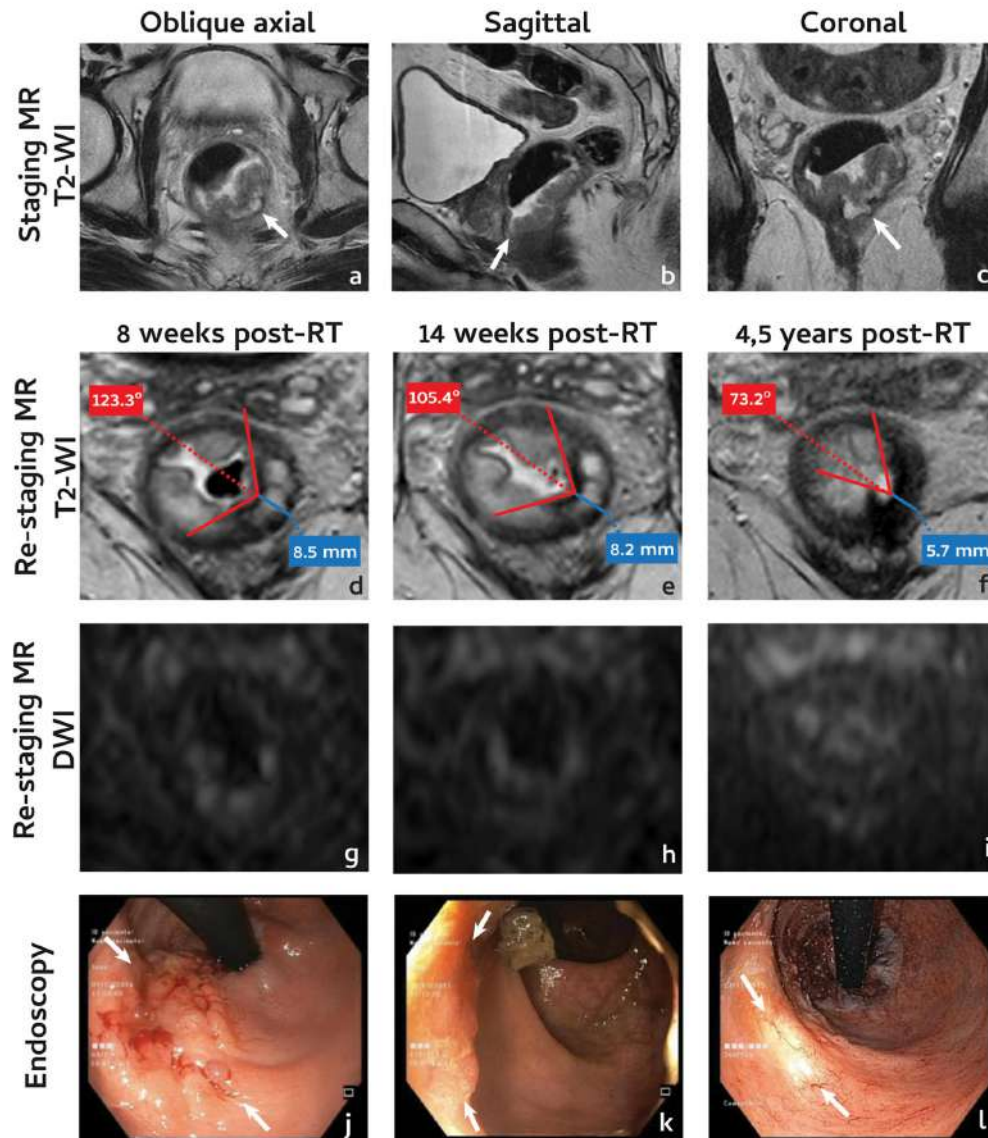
Sixty-six years old male with a low mucinous rectal cancer, mrT3 mrN0 EMVI- MRF + . Tumour abutted the anorectal transition (arrow in b) and invaded left levator ani (arrows in a and c). Patient underwent CRT + adjuvant CT. At first assessment, response was graded mrTRG2 (d) and DWI was inconclusive due to susceptibility artefacts from luminal air (g). On endoscopy, an adenomatous residual mucosal abnormality (grade 2) was found (between arrows in j). At second assessment, DWI was negative and T2-WI and endoscopic findings remained stable (e,h,k) but a clear tumour scar contraction was present (-17.9°) (e). Patient is now at 4.5 years of follow up with a clinical CR and no distant disease recurrence. Now imaging shows a thinner, more fibrotic and concave scar (f) and endoscopy and DWI are negative (l, l).
